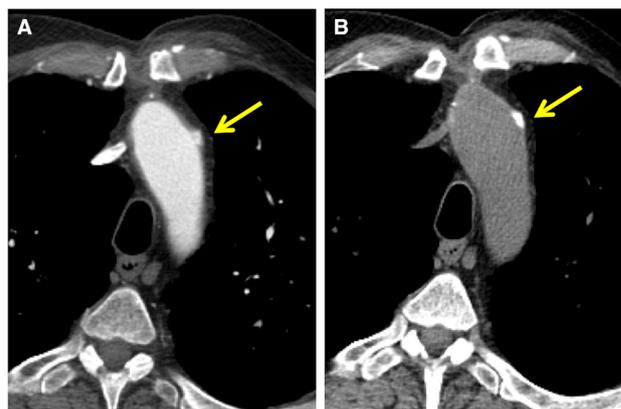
Hyperdense felt pledgets. a Contrast-enhanced CTA image following aortic arch repair. A hyperdense focus along the lateral aortic arch (straight arrow) is suspicious for a pseudoaneurysm. b Non-contrast images demonstrate that this is intrinsically hyperdense and compatible with a surgical pledget
